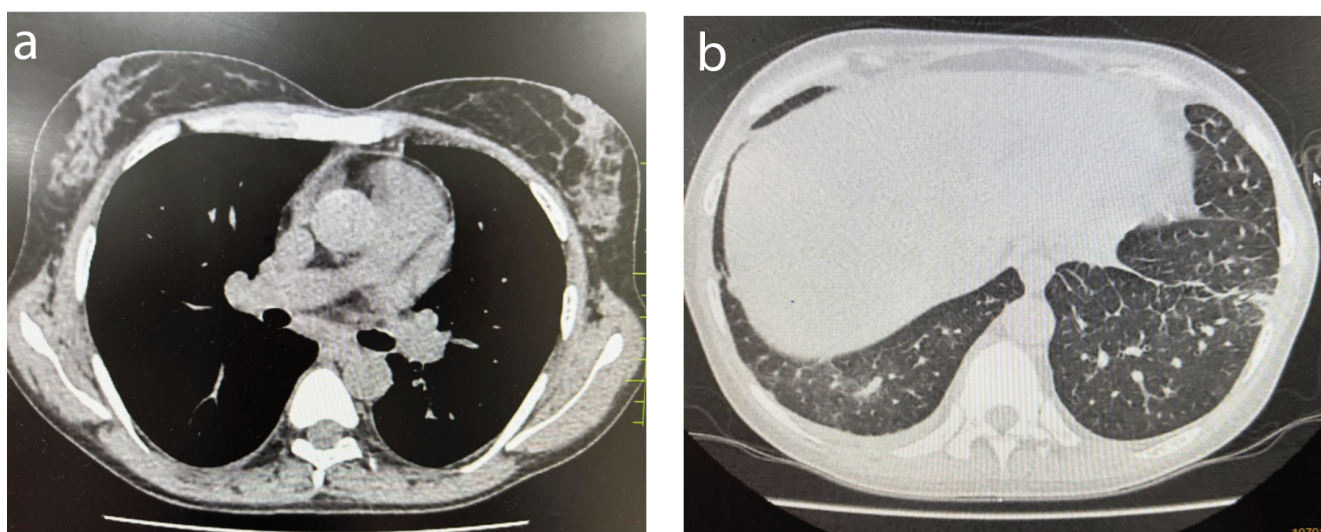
a) Computed Tomography (CT) of the thorax revealing bilateral lower lobe ground glass opacities and b) reticulations with subcarinal and right hilar mediastinal lymphadenopathy.
